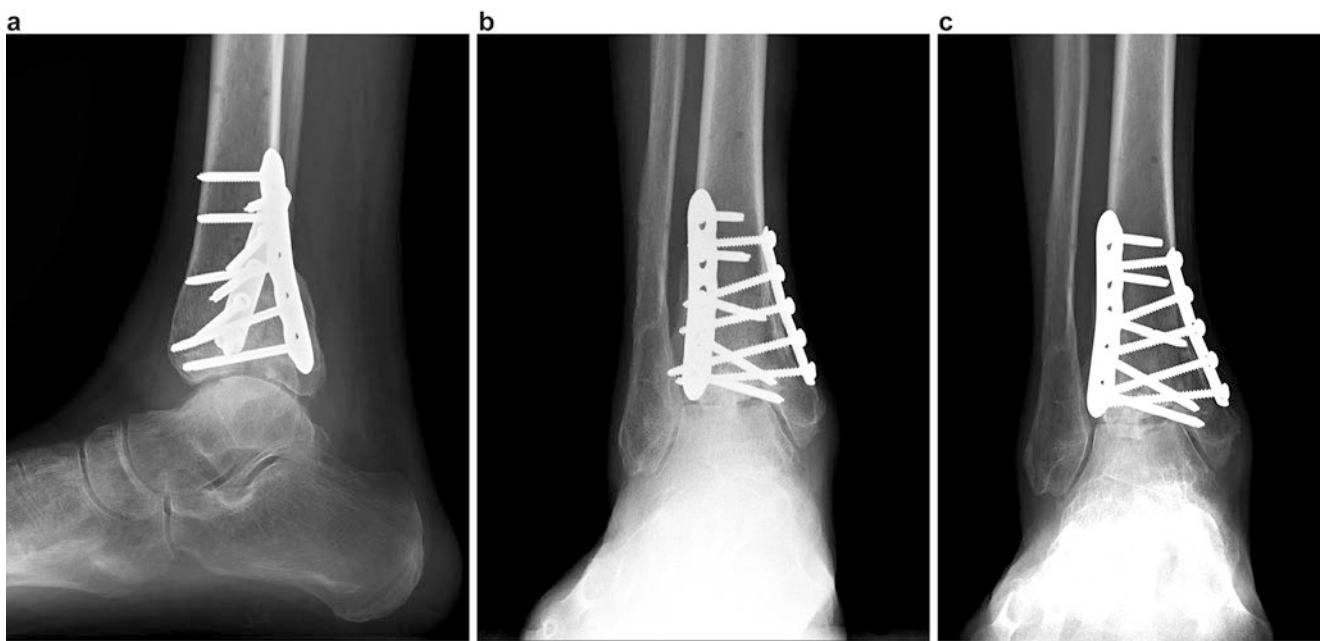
Weightbearing radiographic views of lateral (a), anterior-posterior (b), and mortise (c). Patient is 9 months of postoperative weight-bearing as tolerated
